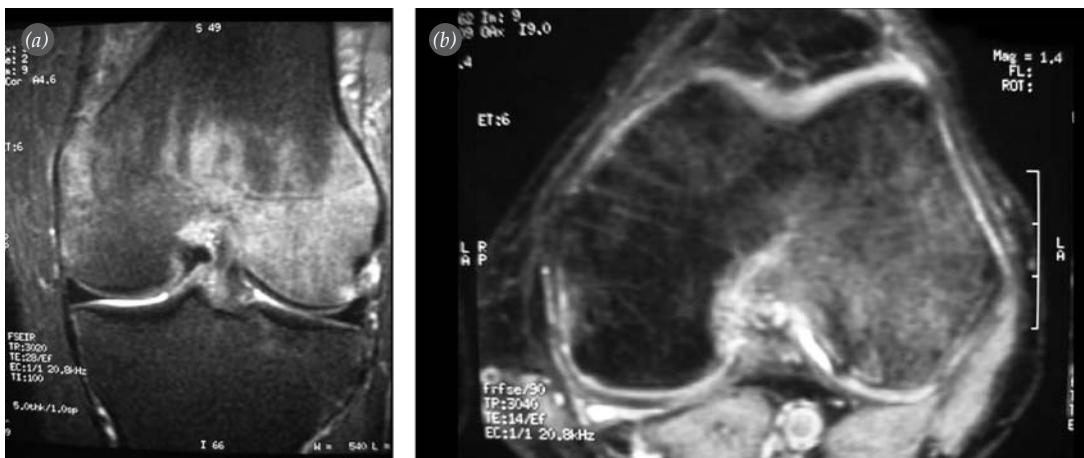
(a) Coronal short-tau inversion recovery (STIR) MR image showing resolution of edema in the medial femoral condyle and development of edema in the lateral femoral condyle. (b) Transverse MR image showing bone marrow edema in the lateral femoral condyle.
